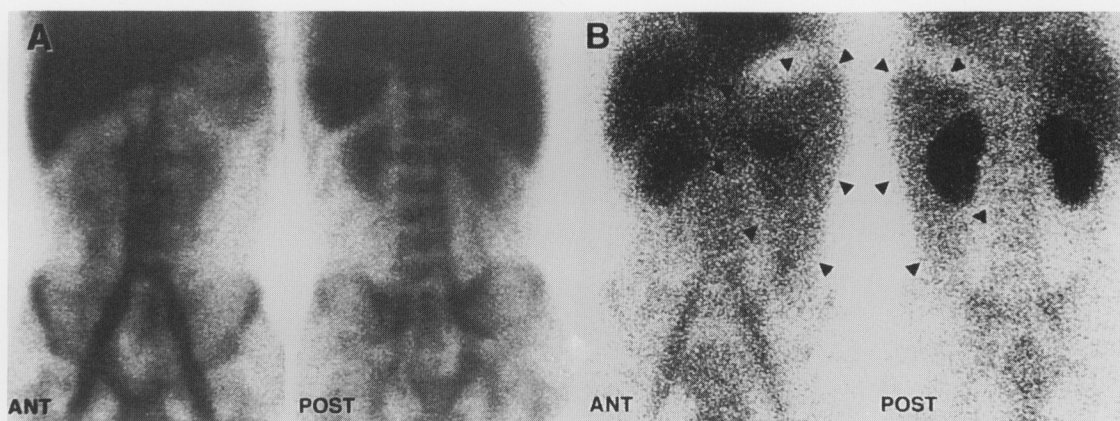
Anterior and posterior abdominal images 5 minutes (A) and 24 hours (B) after the intravenous injection of Tc-99m-DTPA-HSA. Abnormal abdominal activity (arrow heads), which is not appreciable on the blood pool image at 5 min, is seen on the image taken at 24 hours after the injection. The extent of the abnormal activity is the same as seen on the lymphoscintigram, corresponding to the location of the tumor.
